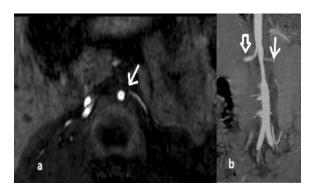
a. Axial section of the magnetic resonance angiography reveals severe renal ostial stenosis (arrow) and decreased renal artery flow. b. Coronal reformatted image of computed tomography angiography reveals mural thickening of the renal and infrarenal level of aorta and left renal artery stenosis (open arrow), decreased flow compared to right renal artery (closed arrow). 264x119mm (96 x 96 DPI)
